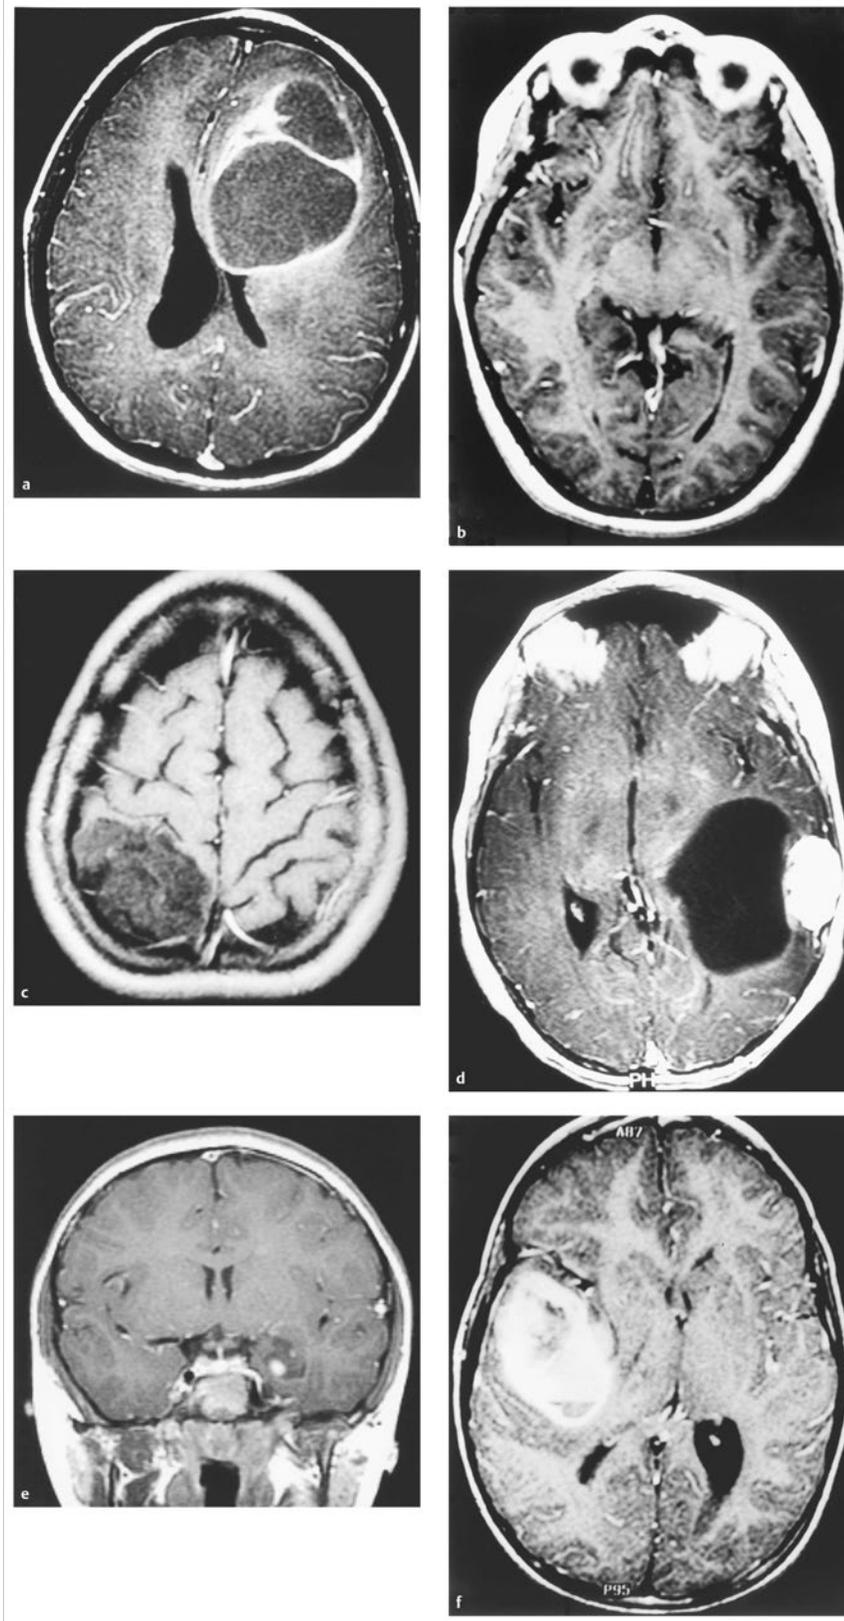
Magnetic resonance images of common supratentorial hemispheric gliomas. (a) Pilocytic astrocytoma. (b) Nonpilocytic astrocytoma. (c) Oligodendroglioma. (d) Pleomorphic xanthoastrocytoma. (e) Dysembryoplastic neuroepithelial tumor. (f) Malignant glioma.
